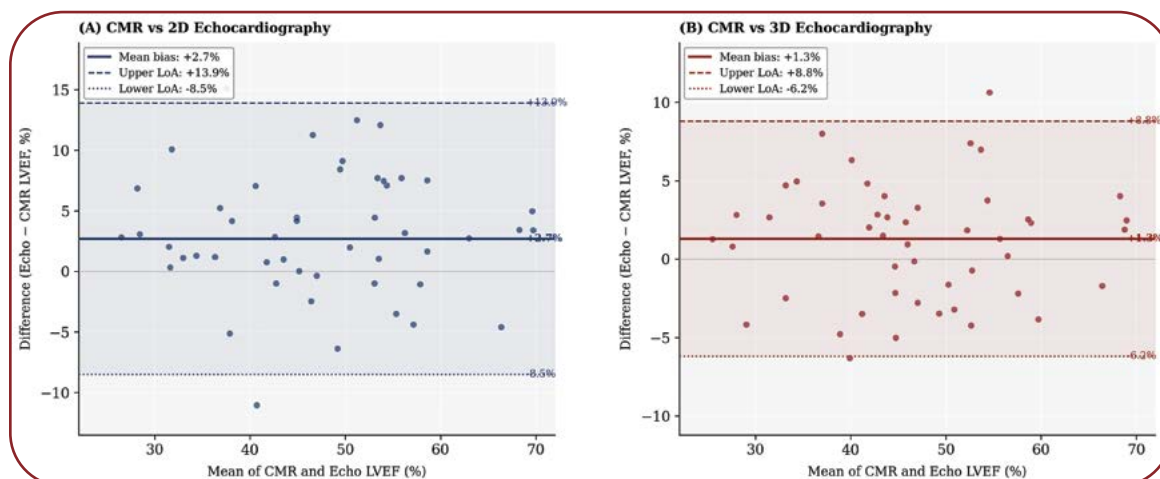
Bland-Altman agreement plots: A) CMR *versus* 2D echocardiography: mean bias +2.7%, 95% limits of agreement -8.5% to +13.9% (total range 22.4 percentage points); and B) CMR *versus* 3D echocardiography: mean bias +1.3%, 95% limits of agreement -6.2% to +8.8% (total range 15.0 percentage points).
